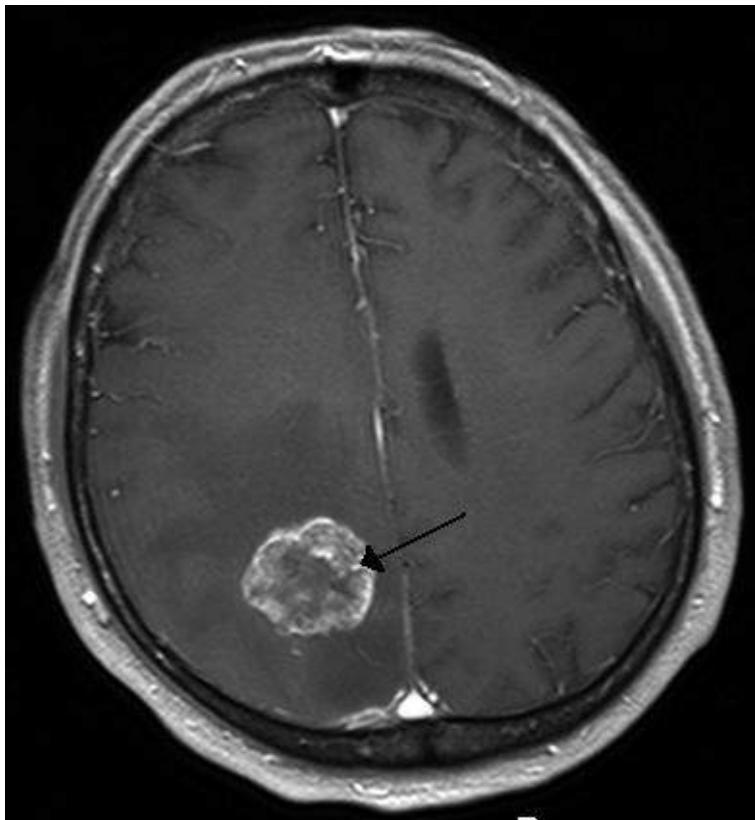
A metastatic tumor in the cerebral hemisphere from lung cancer, shown on magnetic resonance imaging.
